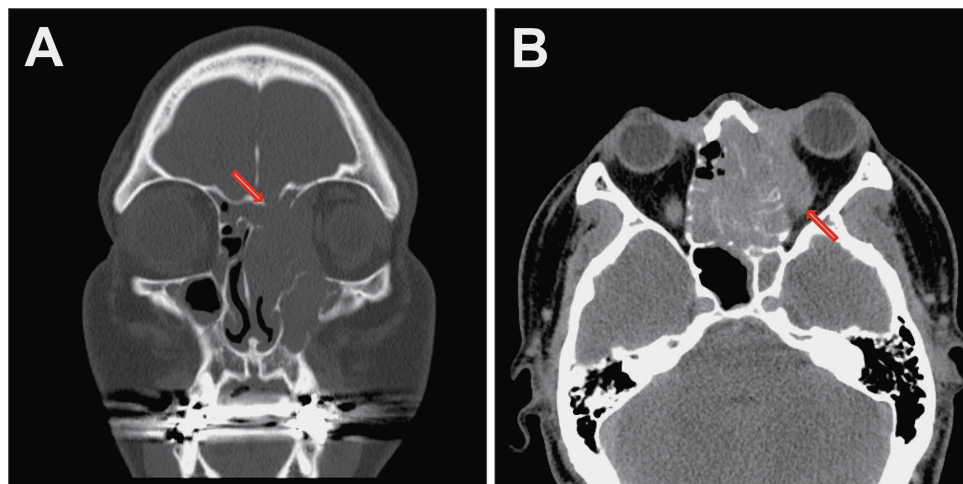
CT scans of the paranasal sinuses.
